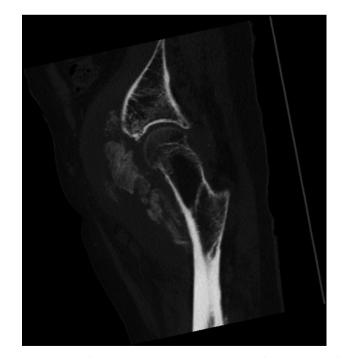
Patient 3: left hip CT scan: immature heterotopic ossifications in the left iliopsoas muscle.
